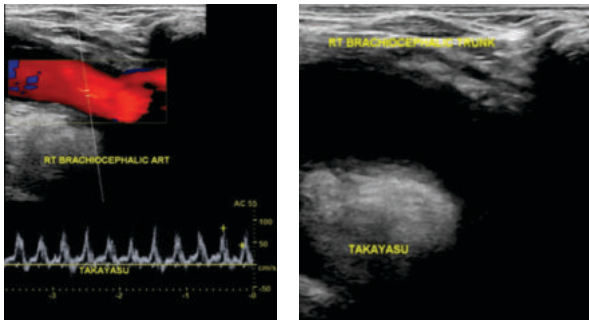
CASE 4: Ultrasound shows involvement of right brachiocephalic trunk.
